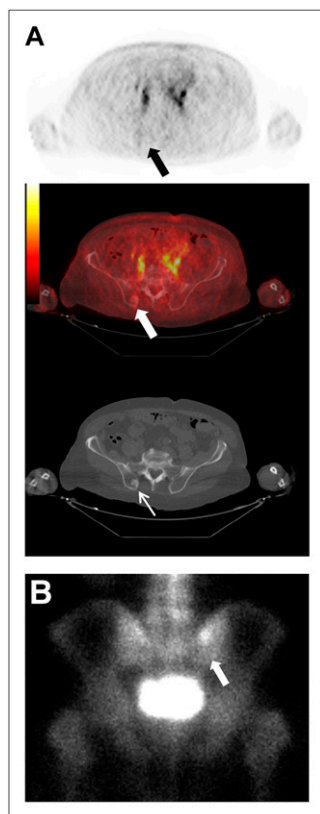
(A) New sclerotic lesion in right posterior iliac bone seen on CT (thin white arrow) but not on ^{18}F -DCFBC PET (black arrow) or PET/CT (thick white arrow). (B) Corresponding asymmetric uptake on bone scan (arrow).
